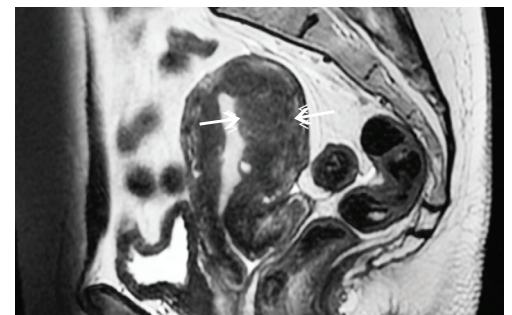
Sagittal MRI image showing thickened junctional zone in adenomyosis in workup for uterine fibroid embolisation for menorrhagia
